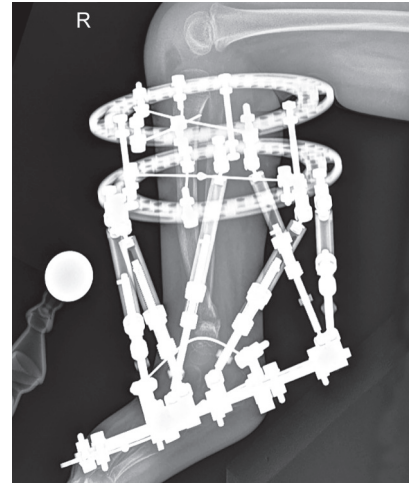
Lateral radiograph showing initial correction post 1st stage supratalar biosseous osteotomy
